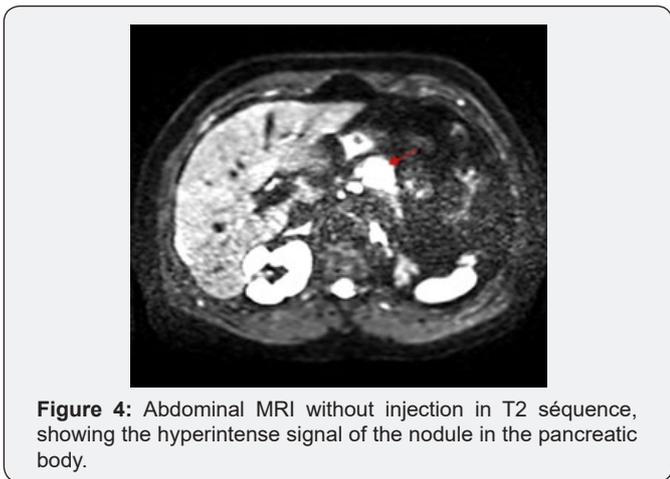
Abdominal MRI without injection in T2 séquence, showing the hyperintense signal of the nodule in the pancreatic body.
